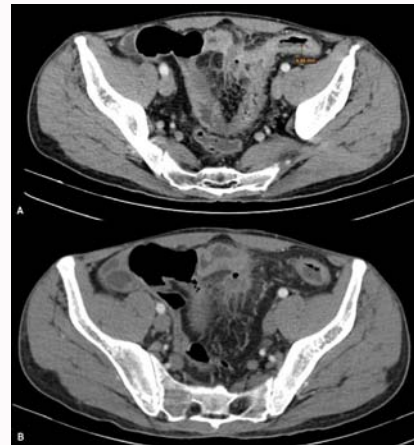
Computed Tomography axial sections venous time showing (A) thickened bowel wall at the descending-sigmoid colon junction, with significant contrast uptake, suggesting inflammatory stenosis at this level. In addition, medially to this segment and in contact with it, there is a gas-fluid collection, with adjacent fat stranding. (B) shows the collection, which is in contact with a small bowel segment, but the images are not specific for a fistula (which remained a suspect, but due to the severity of the symptoms bowel preparation and positive contrast could not be administered to evaluate for extra-intestinal extravasation). Additional findings include engorgement of the vasa recta (the comb sign) and a few enlarged lymph nodes.
